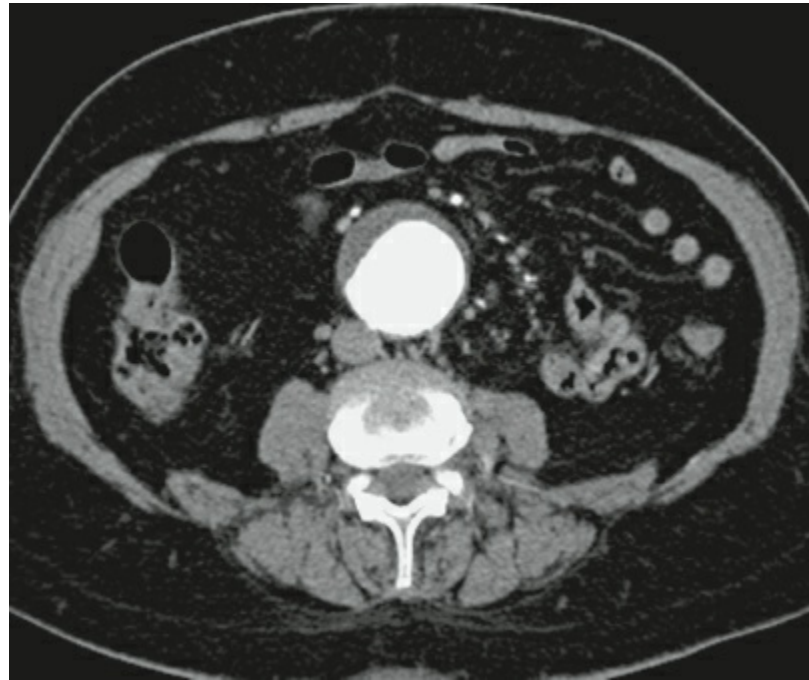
CT scan demonstrates a large abdominal aortic aneurysm. Note that the majority of the lumen is filled with contrast.
